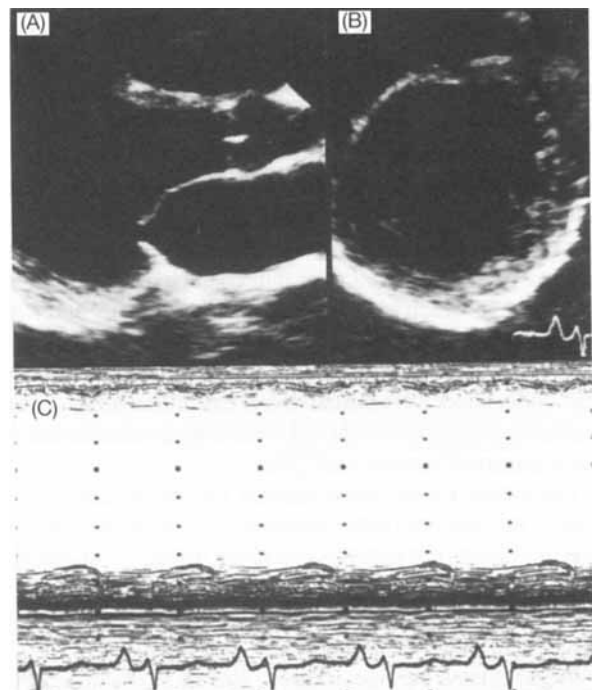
Two-dimensional echocardiogram obtained in the parasternal long-axis view (A) and short-axis view (B), and M-mode echocardiogram (C) in Patient No. 1. The left ventricular (LV) dimension is markedly enlarged and the LV wall is thin. Motion of the interventricular septum and of the LV posterior wall is severely reduced.
